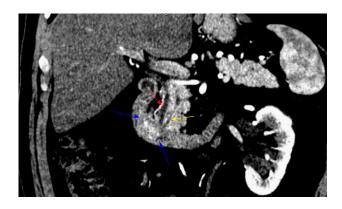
Preoperative computed tomography imaging. Coronal section demonstrating a 2.1 cm × 1.4 cm periampullary duodenal mass (blue arrows). Red arrow: Common bile duct; yellow arrow: Pancreatic duct.
